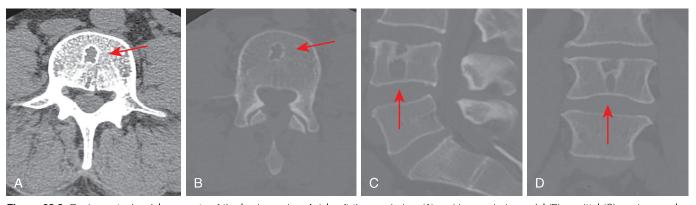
Benign notochordal remnants of the lumbar spine. Axial soft tissue window (A) and bone window axial (B), sagittal (C), and coronal (D) CT images of the lumbar spine demonstrate an L4 notochordal remnant (arrows). Note the elongated contour of this lucent lesion spanning the entirety of the vertebral body. Also note the benign appearance of the lesion with a well-defined sclerotic narrow zone of transition. This lesion was unchanged for several years.
